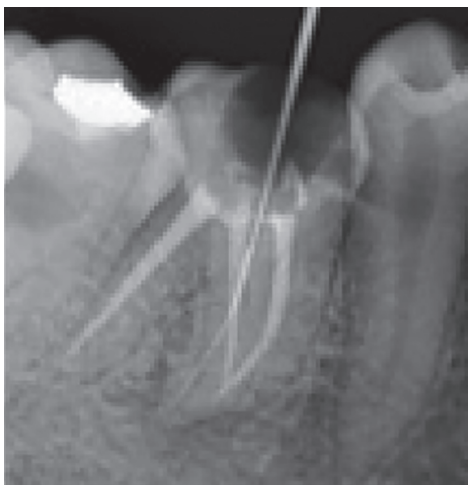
to D: (A) Preoperative view; (B) after instrument retrieval using ultrasonic; (C) after obturation; and (D) recall after 6 months
